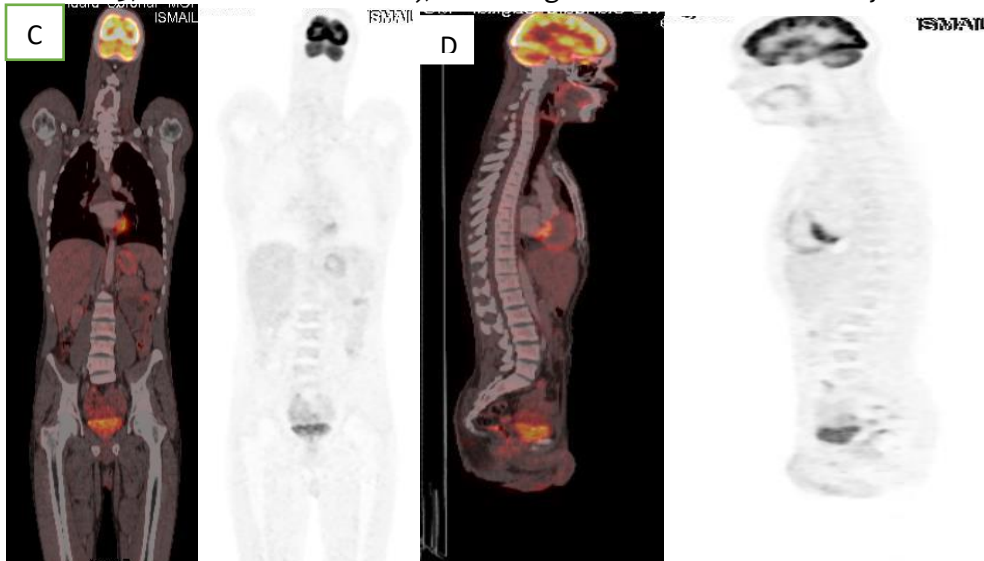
C, D. Coronal and sagittal cuts, respectively, of ^{18}F -FDG-PET/CT of the same patient after (3-4 cycles) of target therapy, revealed Complete metabolic remission of the previously observed uncountable widely spread metabolically active lymphomatous infiltrations
